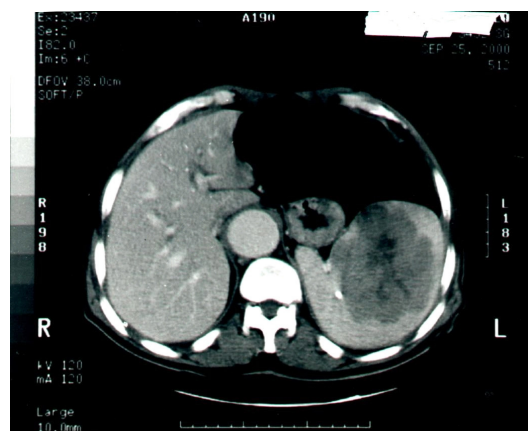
Abdominal computed tomography was demonstrated a large solid tumor mass located in the enlarged spleen.
